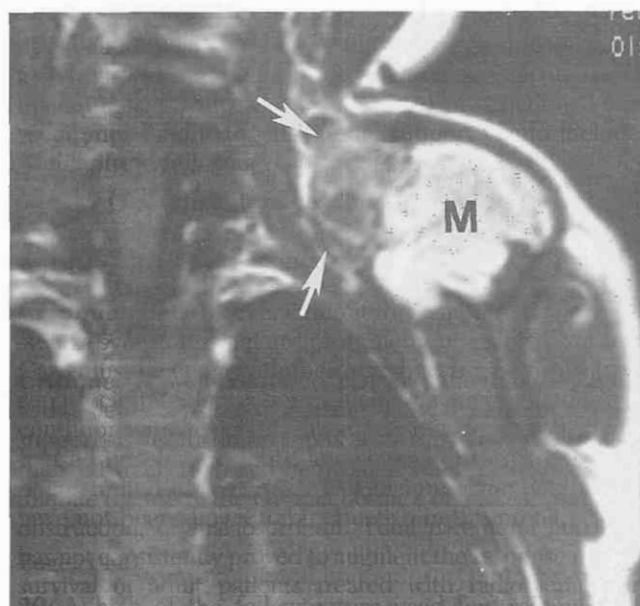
Lipoblastoma of the left supraclavicular soft tissues in a 17-month-old girl. Coronal T1-weighted image (TR = 550 msec, TE = 14 msec) shows a predominantly high-signal-intensity mass (M). The mass paralleled subcutaneous fat on all imaging sequences. An area of lower signal intensity (arrows) represents myxoid degeneration of a portion of the tumor.
